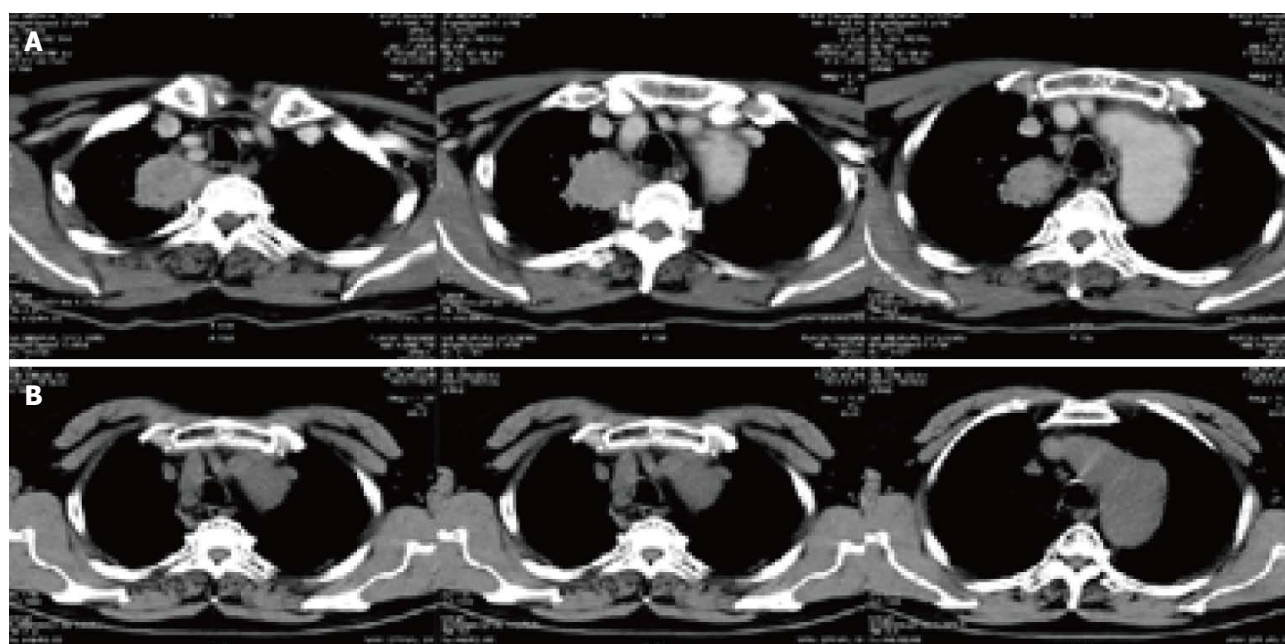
Changes of computed tomography slice before and after treatment in lung cancer patients. A: Right peripheral lung tumor mass (4.5 cm × 4.8 cm × 4.0 cm) located in the right upper lobe of the right lung before treatment; B: The mass disappeared 1 year after treatment.
